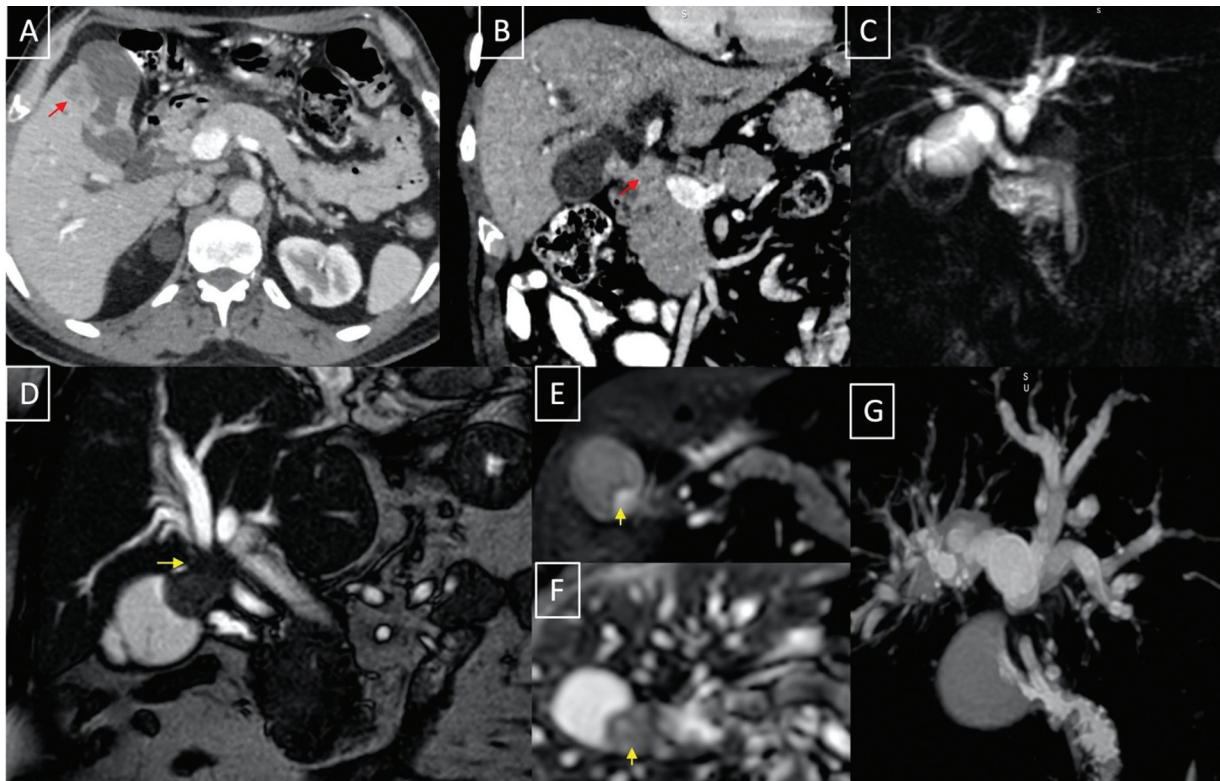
Magnetic resonance cholangiopancreatography (MRCP) depiction of detailed biliary involvement in gallbladder cancer. Axial (A) and coronal (B) computed tomography images show the asymmetric mural thickening of the gallbladder with infiltration into the adjacent liver parenchyma (arrow, A) and periportal lymphadenopathy (arrow, B) causing biliary cutoff, just below the primary confluence. Corresponding MRCP image (C) shows the exact site and extent of biliary involvement which is important for surgical and biliary intervention planning. T2-weighted coronal image (D) of another patient shows a malignant gallbladder mass (arrow) showing diffusion restriction (E [diffusion-weighted imaging [DWI] 800], F [apparent diffusion coefficient [ADC]]), involving the bile duct, just below the primary confluence which is well depicted by the MRCP image (G).
